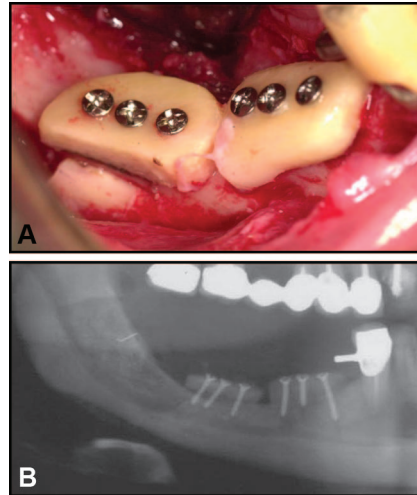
Clinical (A) and radiographic (B) views of the first tier of bone blocks following fixation in the recipient site.
